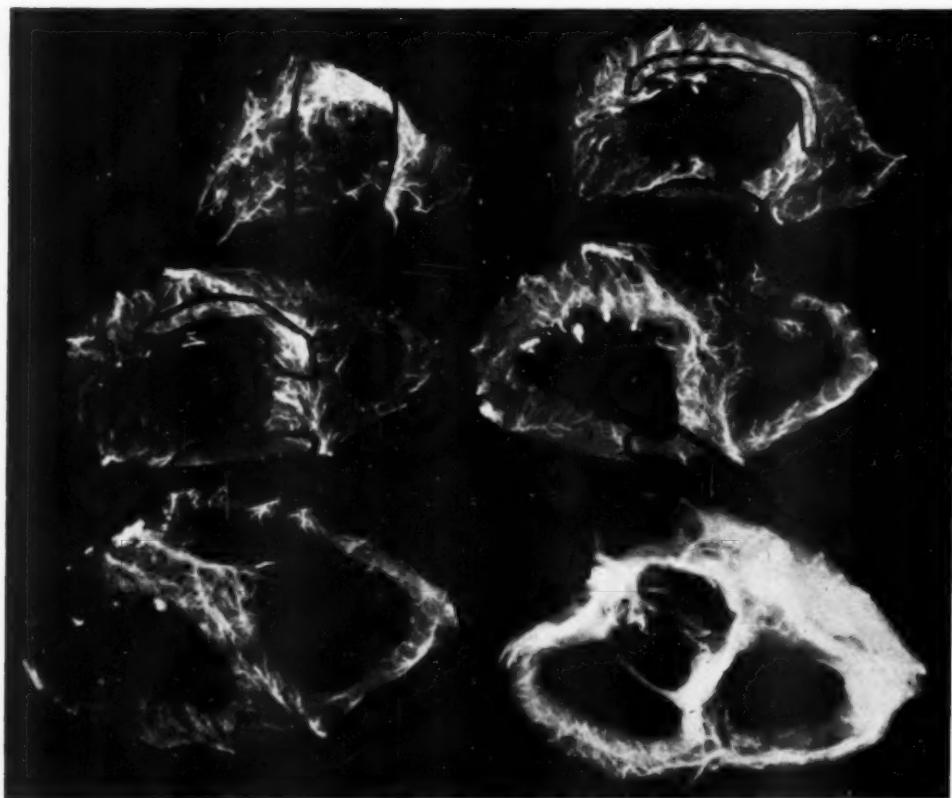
Roentgenogram of the injected heart in Case 63.
